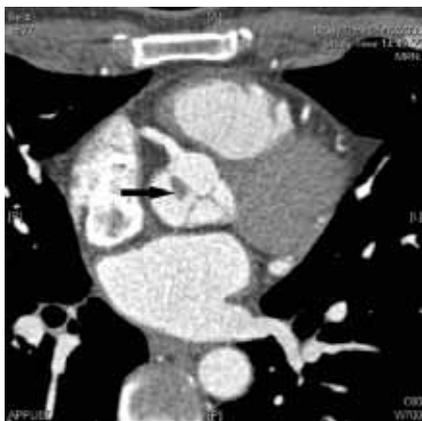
64-slice cardiac computed tomography cross-sectional multi-planar reconstruction showing a filling defect attached to the aortic valve.
